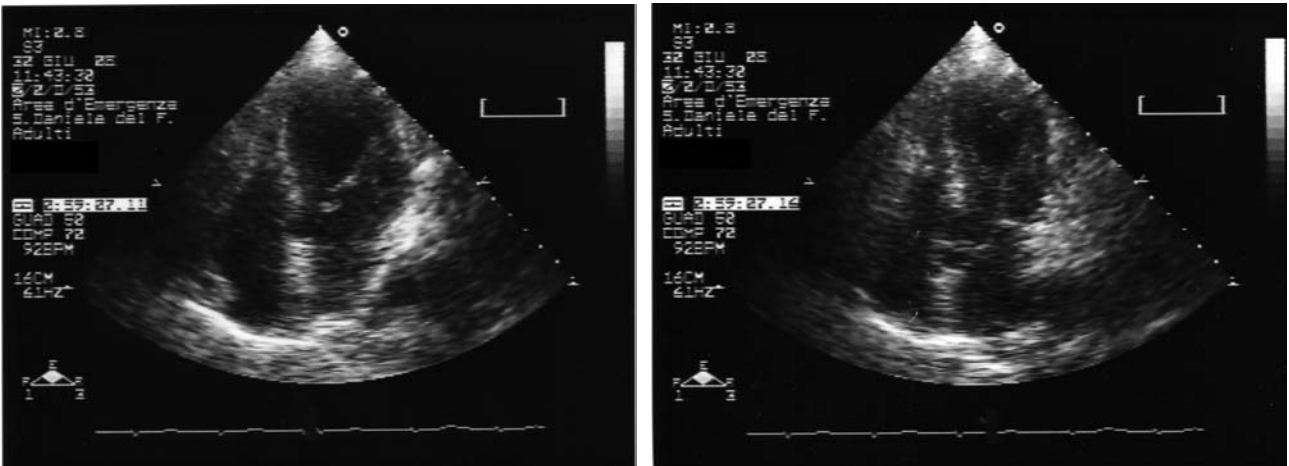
Echocardiogram in diastole (left panel) and in systole (right panel).
